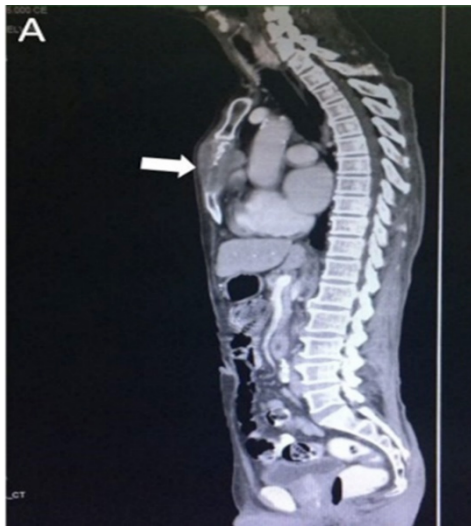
Sagittal view of CT of thorax revealing an aggressive lytic lesion of the body of sternum (white arrow)
